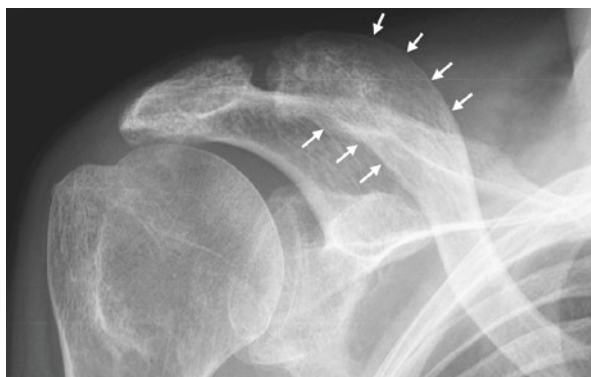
Radiographic findings – acromioclavicular joint
